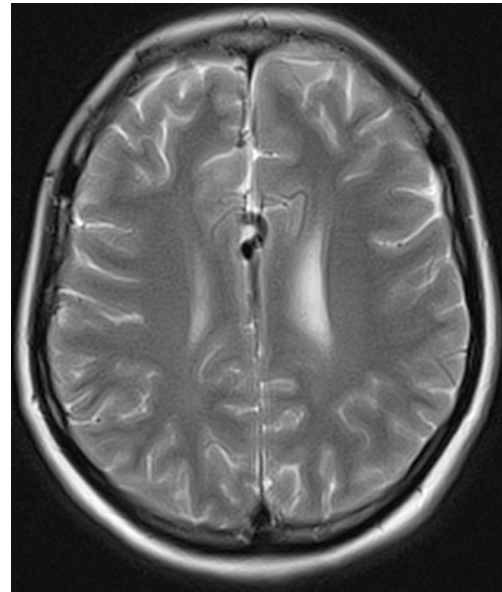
T2-weighted axial magnetic resonance imaging scan at 2 years after SRS
